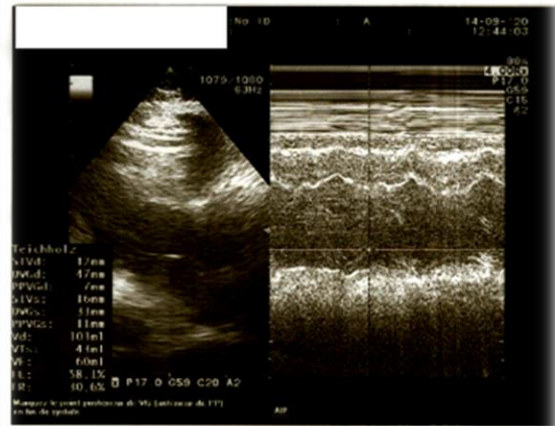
Echocardiography Doppler
